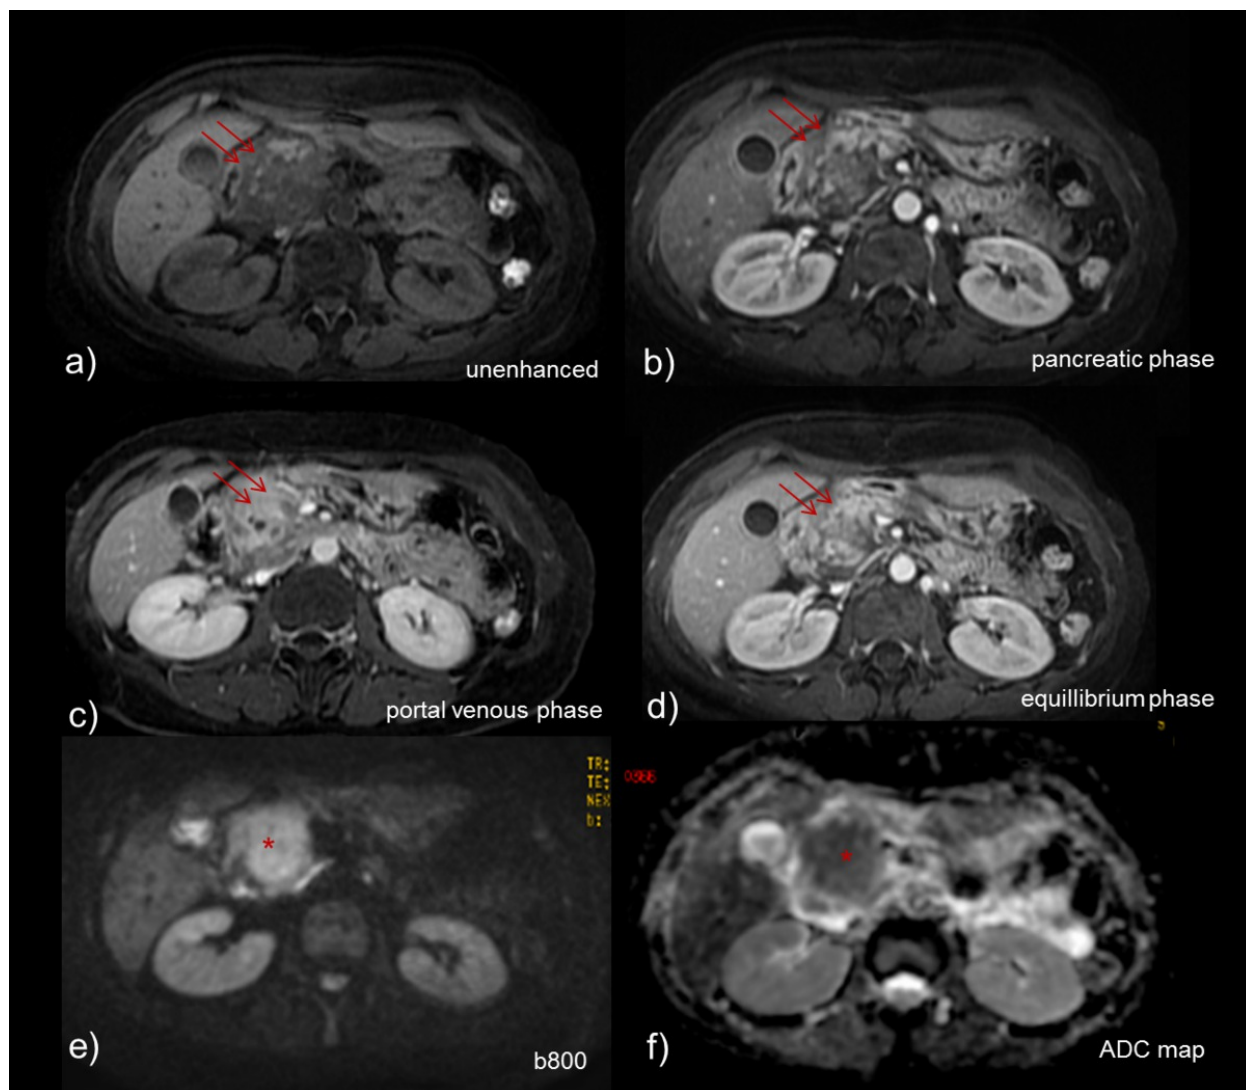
Axial T1 3D fat-saturation images a) b) c) d) , axial DWI b-800 image e), ADC map f) of a patient with a hypointense mass at the pancreatic head (arrows), enhancing only in portal venous phase favoring inflammatory origin (usually adenocarcinomas enhance typically in more late phases). The lesion demonstrated restricted diffusion with low ADC values (*), however diffusion-weighted imaging doesn't allow differentiation between malignant and inflammatory masses.
